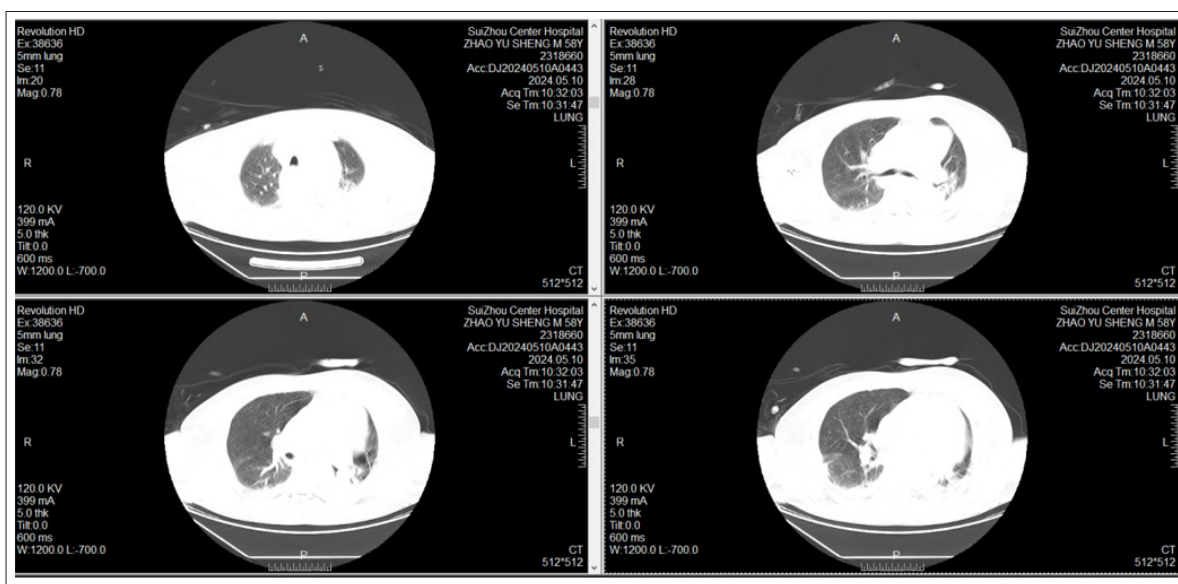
Lung CT on May 10 showed multiple ground glass nodules without obvious nodules in the lower lobes of both lungs
